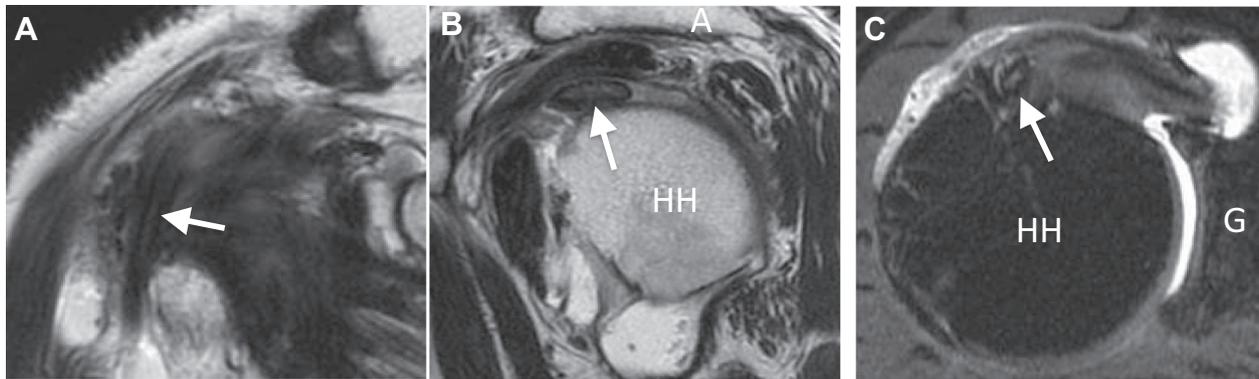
Representative case of partial tears of LHBT in conventional-slice MRI. (A) Oblique coronal image. LHBT increased intratendinous signal (arrow). (B) Oblique sagittal image. LHBT was thickening (arrows). (C) Axial images. LHBT increased intratendinous signal (arrow). A, acromion; G, glenoid; HH, humeral head.
